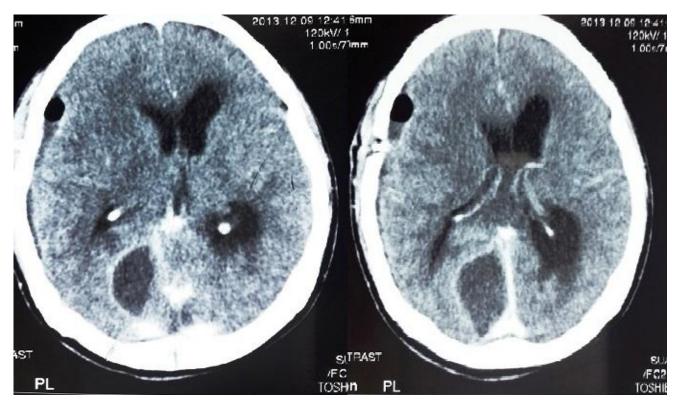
Post Operative initial CT scan showing the parafalcine occipital subdural empyema left.
